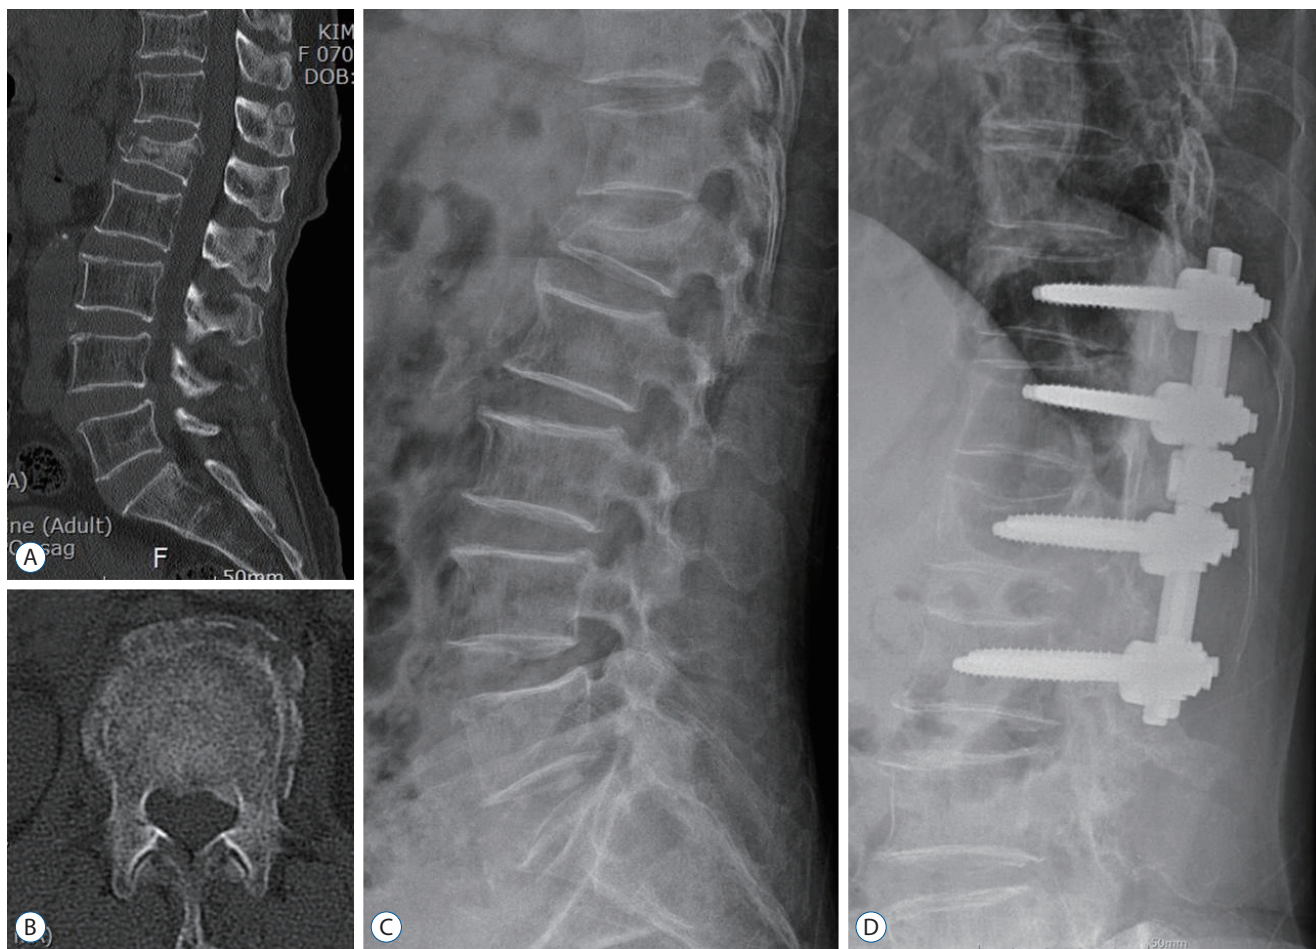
A 71-year-old female patient with a L1 burst fracture (thoracolumbar injury classification and severity score 5 and McCormack's load sharing score 7) was treated surgically with screw fixation and posterior fusion. Sagittal (A) and axial (B) view of computed tomography at baseline shows L1 burst fracture with $\geq 50\%$ of compression ratio and retropulsed bony fragment. Lateral plain X-ray at 12-month (D) shows restored kyphotic, segmental vertebral kyphotic angle, and vertebral heights with bone fusion compared to baseline (C).
